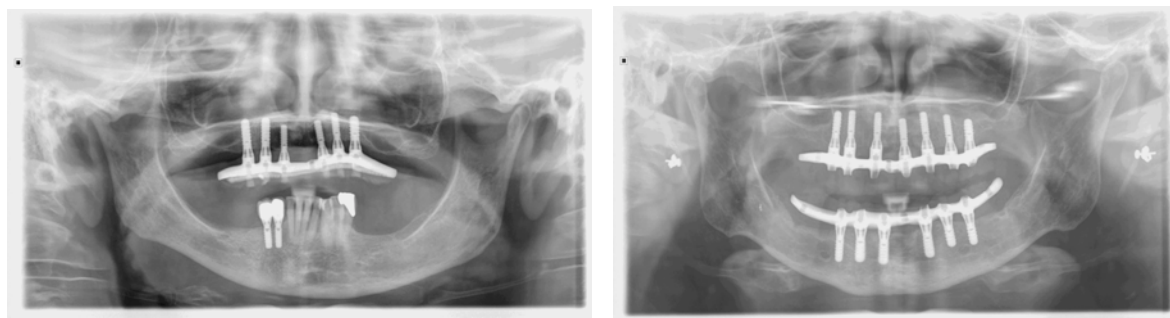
Post-op panoramic X-rays
